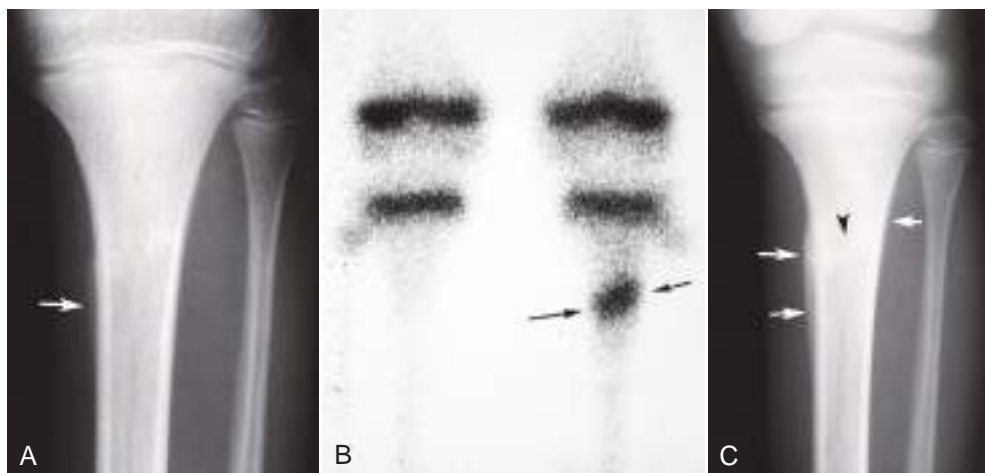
Proximal tibia stress fracture. (A) Radiograph shows ill-defined lamellar periosteal bone formation in proximal medial tibial diaphysis (arrow). (B) Bone scan shows oblique transverse stress fracture in the proximal tibia (arrows). (C) Frontal tibial radiograph obtained 3 weeks later demonstrates progressive formation of periosteal new bone formation (arrows) and appearance of subtle linear sclerosis at the stress fracture site (arrowhead).
